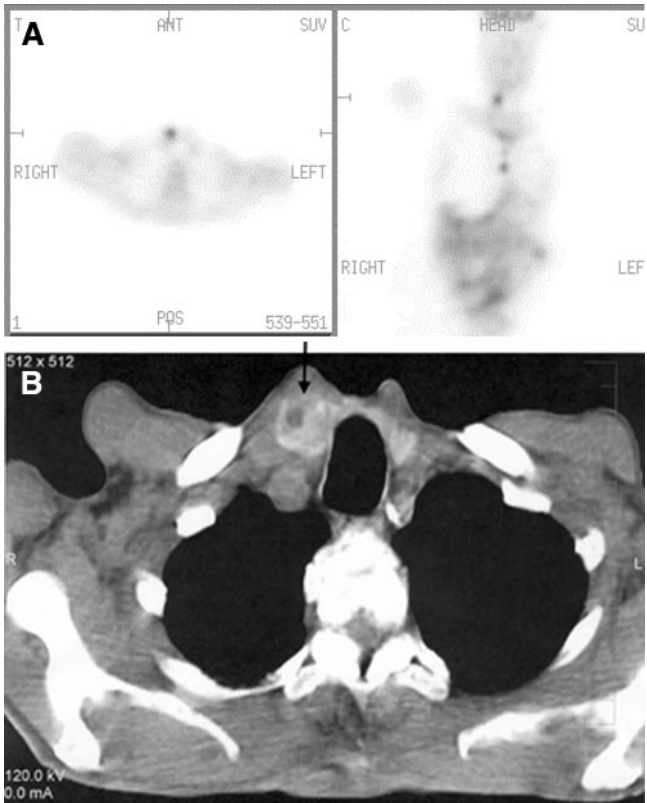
Focal thyroid uptake. (A) Focal thyroid uptake seen in right lobe of thyroid gland corresponding to focal density (arrow) seen on CT scan (B). ANT = anterior; POS = posterior; C = coronal.
